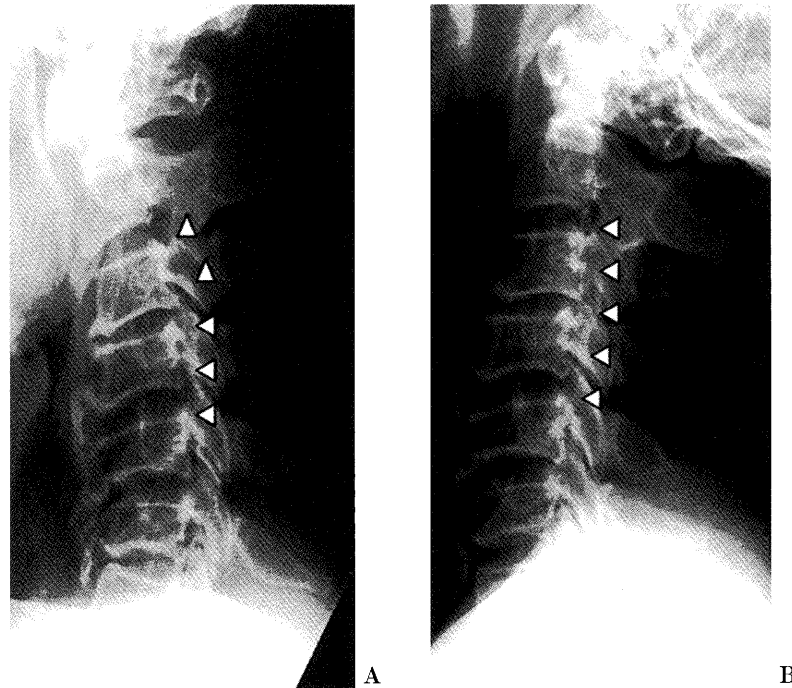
Lateral X-rays showing OPLL (*arrow heads*) at the C3 to C7 levels with marked anterior osteophytes. Range of motion in flexion A. and extension B. X-rays are limited to 15° of kyphosis in flexion and 2° of kyphosis in extension between C2 and C5.
